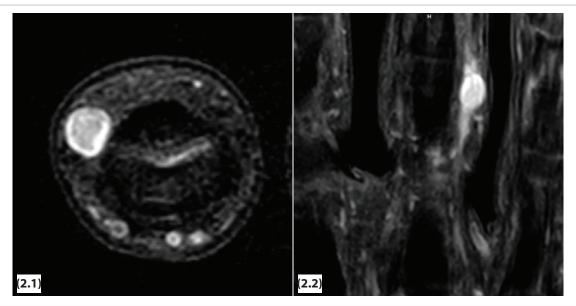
MRI images showing the nerve tumour with dimensions 4,7*4,5*20,0mm. The lesion was slightly hyperintense on proton density fat saturated (PD fat sat) image with strong and heterogenous contrast enhancement. Axial view (Figure 2.1) and coronal view (Figure 2.2).
